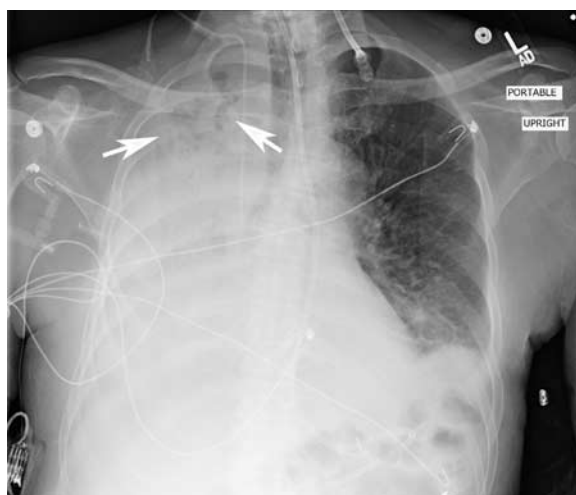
Bronchopneumonia due to community-acquired MRSA pneumonia. Chest radiograph of an 88-year-old man shows an extensive opaque right hemithorax. Irregular air-filled small cavities (arrows) are seen in the right upper lobe (arrows).
